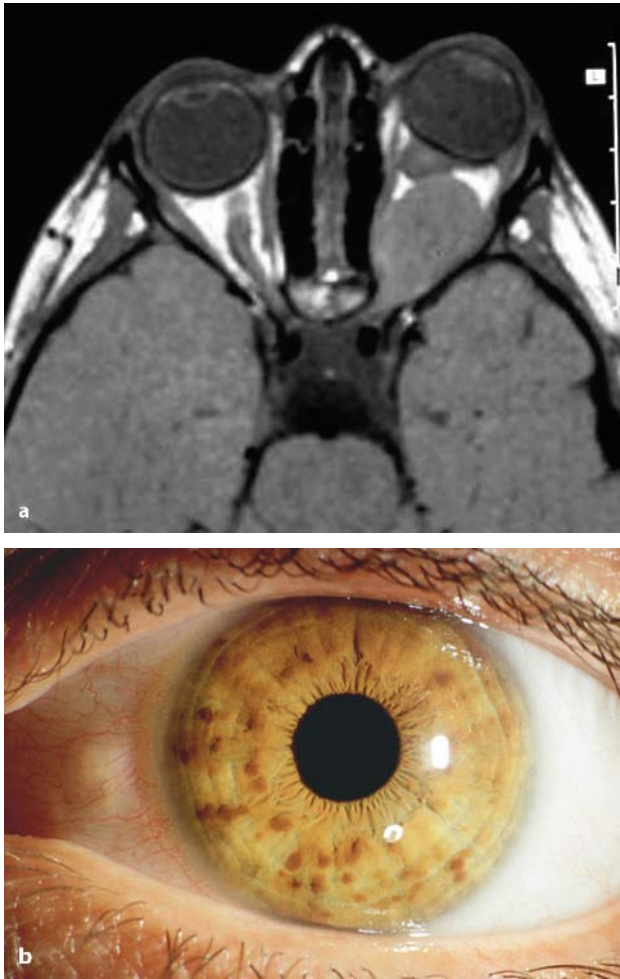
a Optic nerve glioma (MRI). It is important to note that the nerve itself is enlarged, in contrast to the appearance of an optic sheath meningioma. Kinking or sharp angulation of the optic nerve is also very characteristic. Gliomas of the optic nerve frequently occur in the setting of neurofibromatosis type 1 (NF1). Depending on the location of the tumor, optic disc swelling may be seen at the time of discovery. In later stages, a partial or complete optic atrophy will be apparent. b Lisch nodules are typical in NF1, but may not be apparent during childhood
